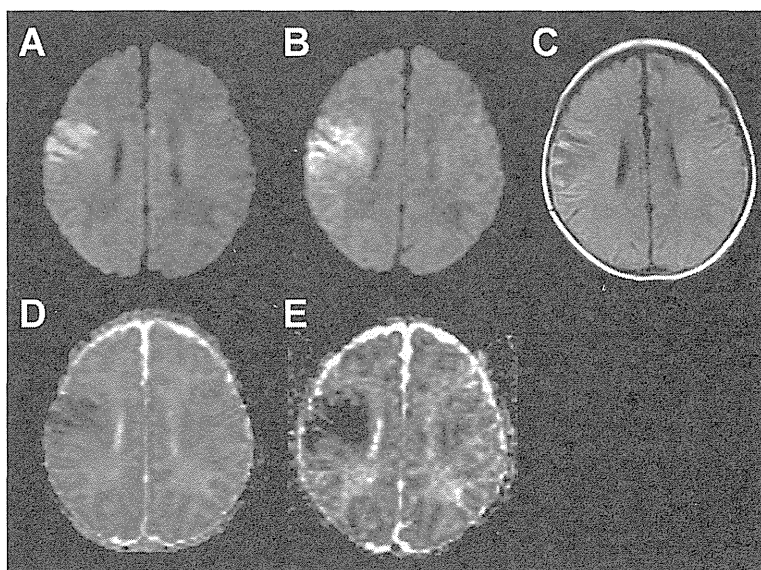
Diffusion-weighted imaging (A and B) and T1-weighted imaging (C) in patient #1. (A) Cortical lesion in the right front temporal lobe, 17 h after onset; (B) extending to the subcortical white matter in the same area at 40 h after onset; (C) the lesion evolved into areas of encephalomalacia by day 14. The distribution of high-signal lesions on (A) and (B) corresponded to the low diffusion area in apparent diffusion coefficient maps (ADC) (D) and (E), respectively.
